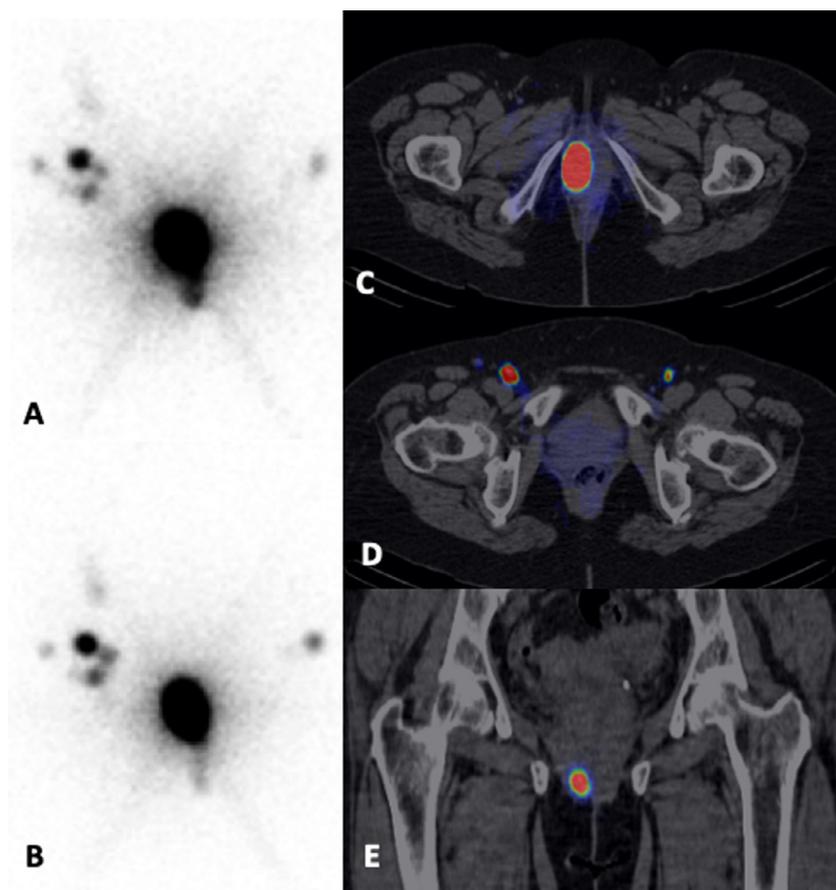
A 67-year-old patient with right sided vaginal melanoma. underwent sentinel lymph node scintigraphy. After two injections of about 30 MBq each in the periphery of the scar, several focal uptakes were observed in planar acquisitions at 10 and 60 minutes (A and B). The fused SPECT/CT views showed the injection site (C and E) and bilateral lymph node uptake in the inguinal areas (D). All nodes showed no metastatic spread.
